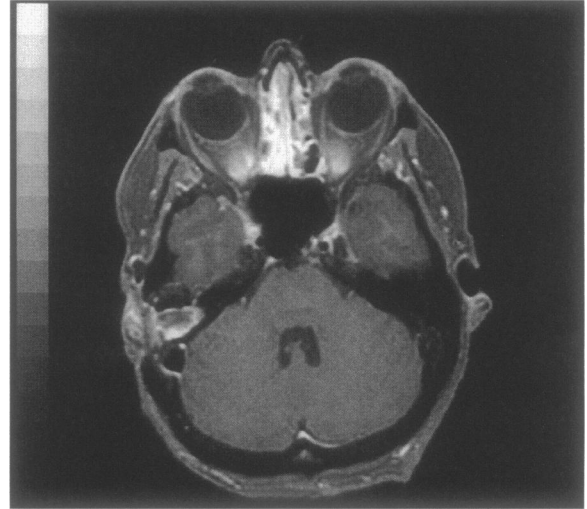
MRI demonstrating no increase in the size of the tumor after 36 months on somatostatin therapy.
